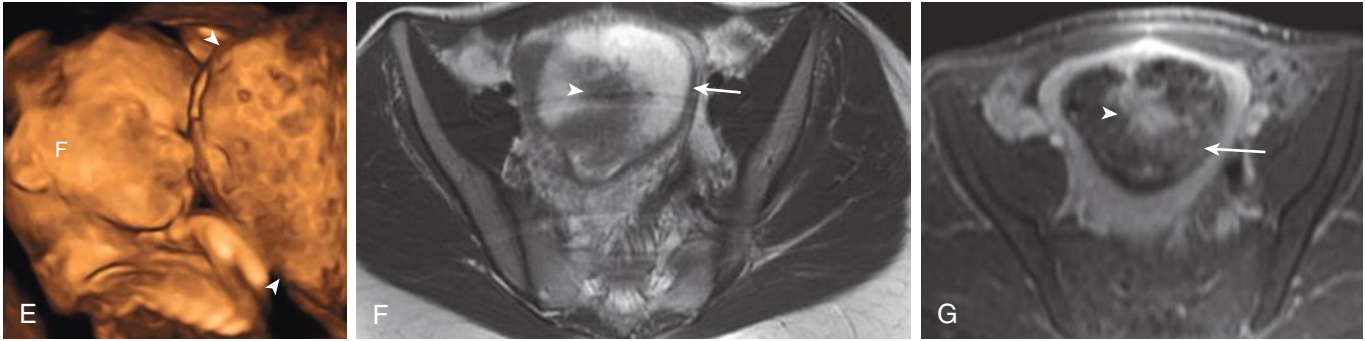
cont'd E, Three-dimensional sonogram demonstrating normal fetus (F) with CHM (*arrowheads*) twin gestation. F, Axial T2-weighted MRI image demonstrates an enlarged uterus and endometrial cavity filled with high signal cystic areas (*arrow*) with central low signal more solid-appearing tissue (*arrowhead*). G, Axial postcontrast fat-suppressed MRI image confirms central more solid enhancing core (*arrowhead*) and surrounding lacelike enhancement of cystic tissue (*arrow*). No extrauterine extension is seen.
